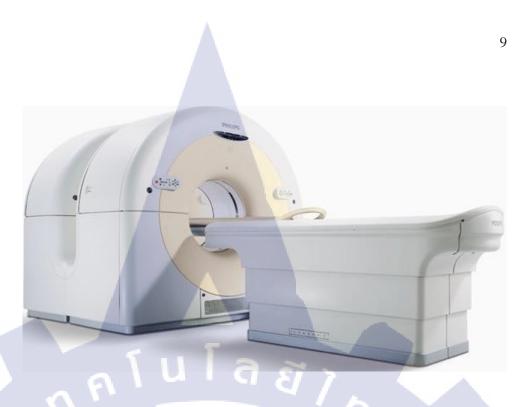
PET/CT Scanner.
